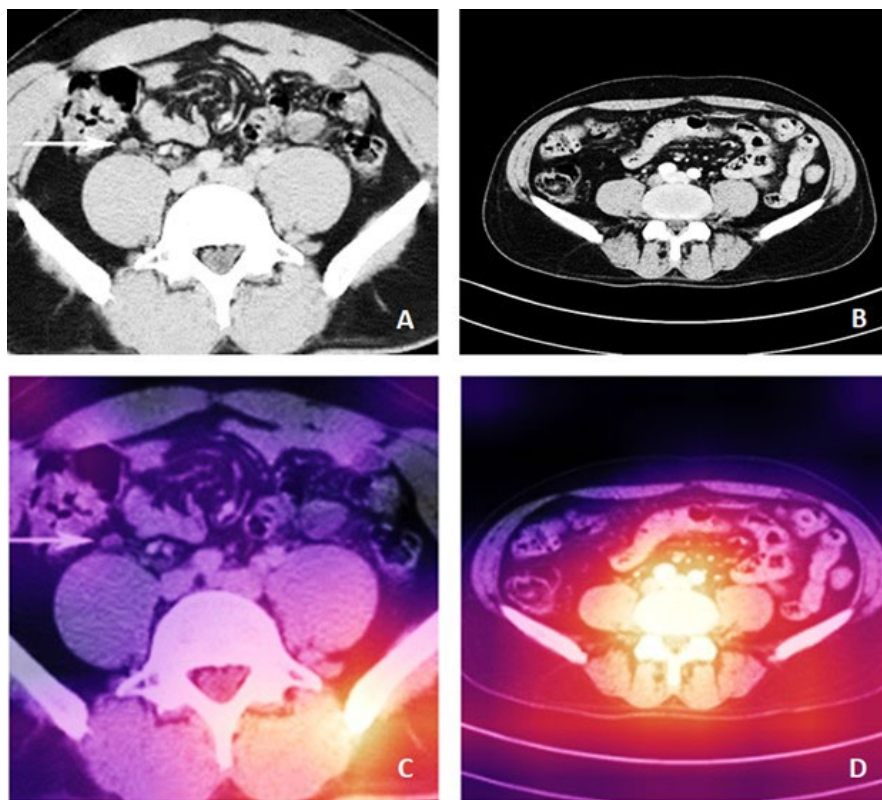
Example of input grayscale CT images for a patient with abdominal lymphadenopathy (A) and a healthy control (B). Output colored activation maps of the same CT images for a patient with abdominal lymphadenopathy (C) and a healthy control (D).
